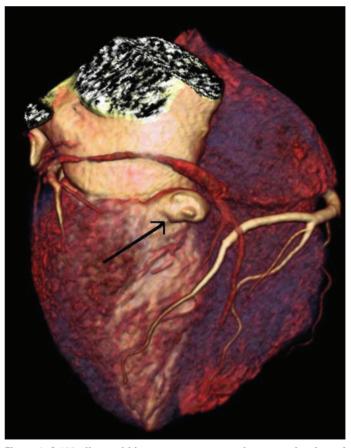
A 128-slice multidetector-row computed tomography view of the submitral left ventricular aneurysm (1.3x1.1 cm in size) (arrow)
